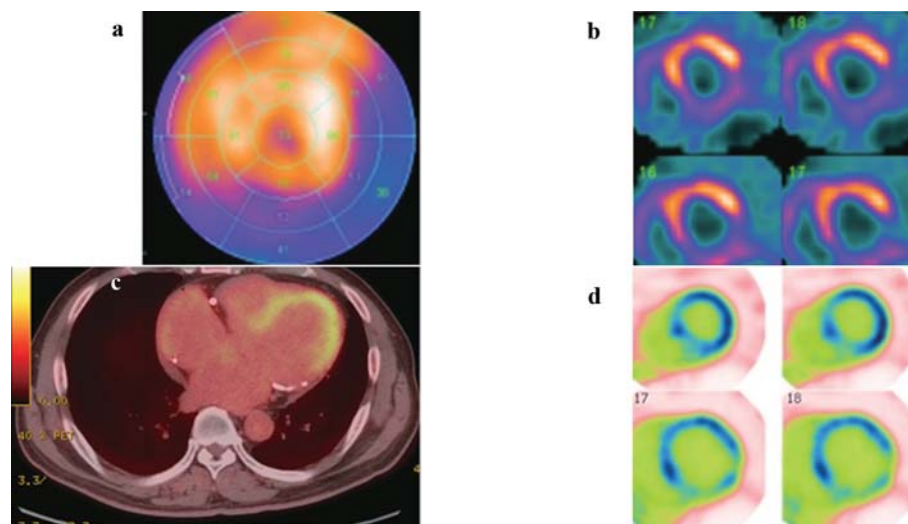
Cardiac PET/CT for the assessment of viability
